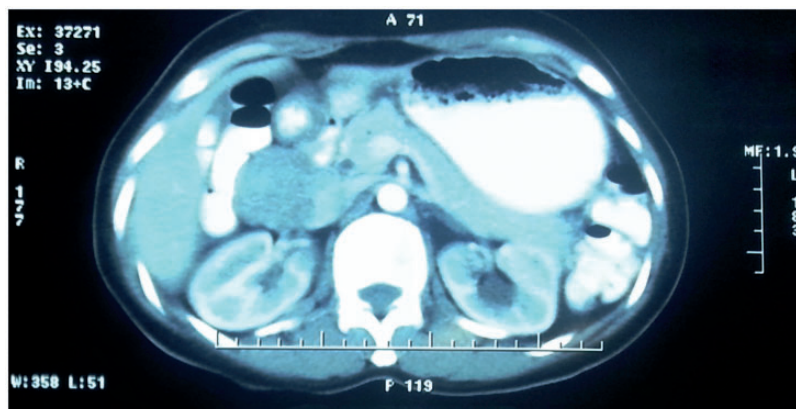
Computed tomography one week postoperatively.
